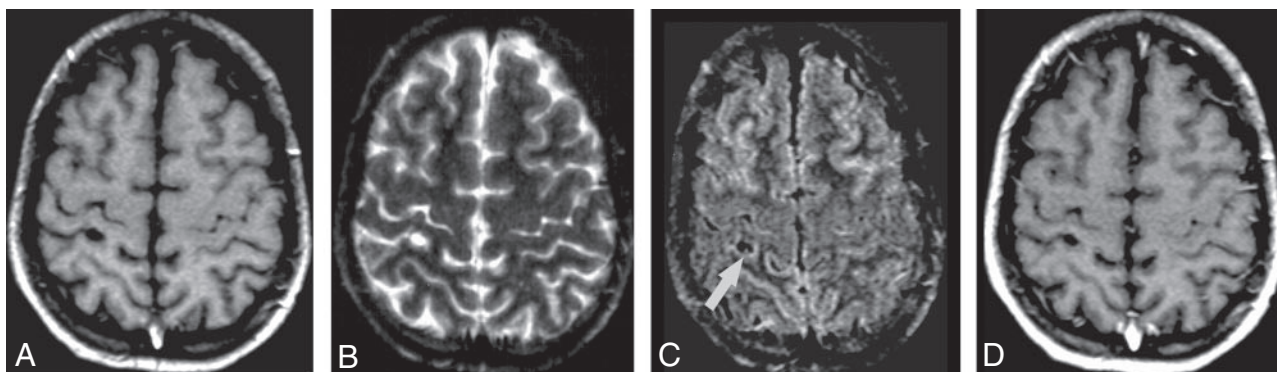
Axial T1-weighted (A), axial T2-weighted (B), axial FLAIR (C), and gadolinium-enhanced axial T1-weighted (D) images demonstrate that the ability to detect the scolex is present, in this case, only in the FLAIR image (arrow in C).
